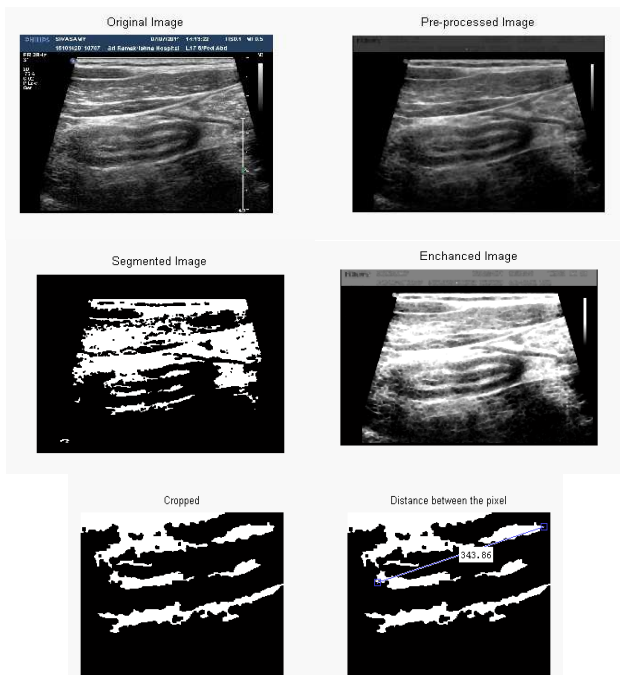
Automatic Appendicitis Detection on Sonographic Images
